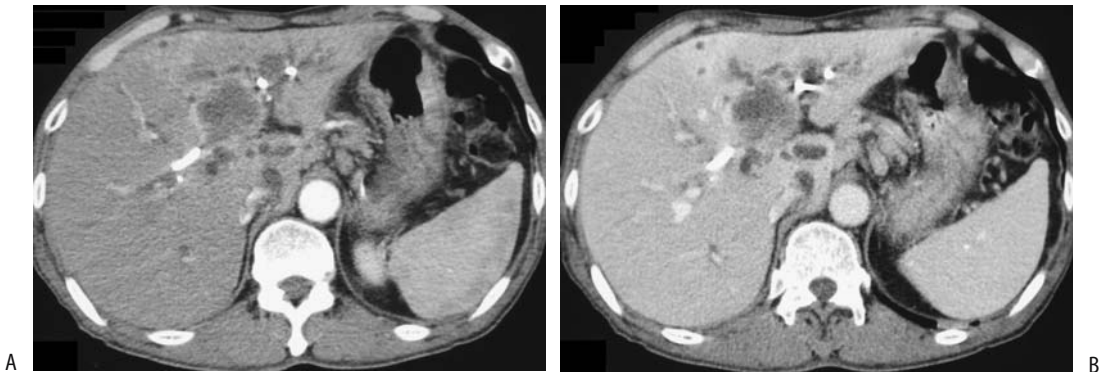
Hilar cholangiocarcinoma. Arterial- (A) and portal-phase (B) CT identifies a hypodense tumor. Catheters are in place in dilated intrahepatic ducts. (Source: Han JK, Choi BI, Kim AY, et al. Cholangiocarcinoma: pictorial essay of CT and cholangiographic findings. *RadioGraphics* 2002;22:173–187, with permission from the Radiological Society of North America.)
